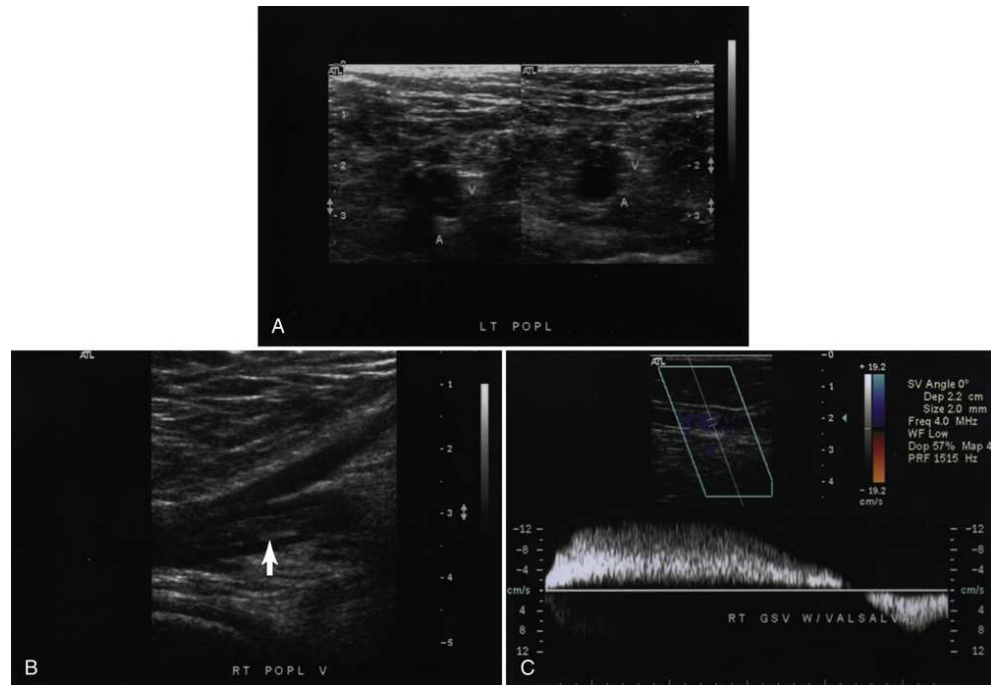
(A) Transverse sonograms of popliteal artery and vein without compression (*left image*) and with compression (*right image*) showing a deep vein thrombosis. (B) Sagittal sonogram of popliteal vein showing echogenic thrombus (*arrow*). (C) Spectral analysis of great saphenous vein shows venous reflux during Valsalva maneuver signifying venous incompetence at this level.
